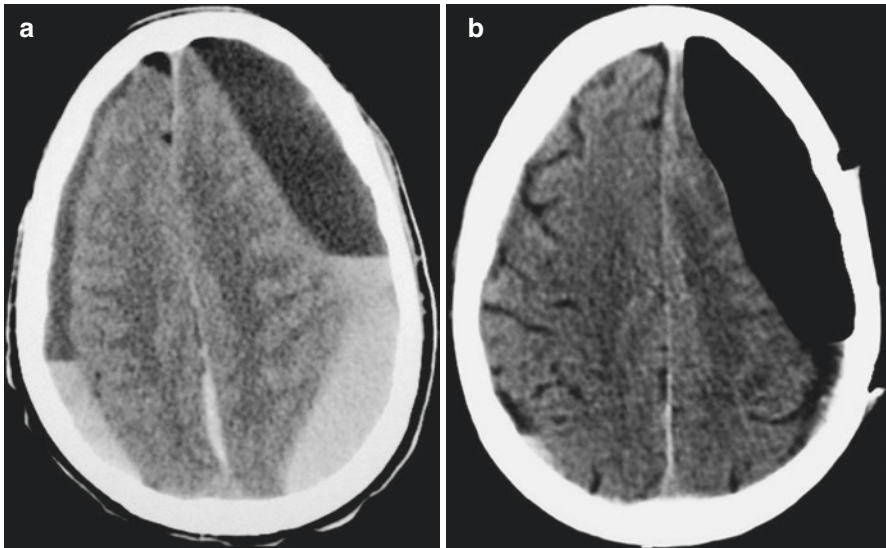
Unilateral postoperative tension pneumocephalus following burr holes surgery for chronic SDH. Initial cranial axial CT scan (a) and on the third postoperative day (b)
